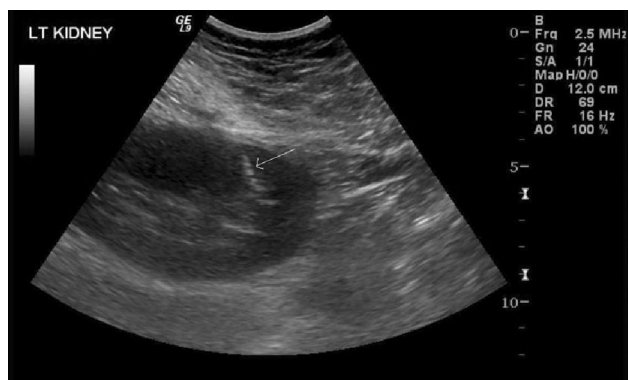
Sagittal sonogram obtained during renal biopsy of 35-year-old male shows needle path (arrows) through the cortex at lower pole with needle directed caudally.
